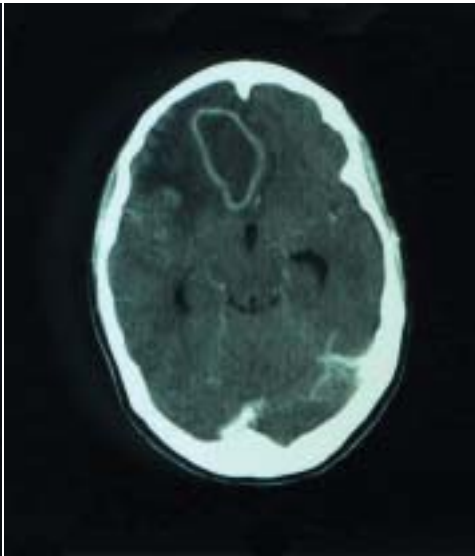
She represented 5 weeks later with similar symptoms. Her CRP and white cell count were normal. This contrast enhanced CT scan shows the characteristic appearances of an intracerebral abscess with a thin walled cavity surrounded by cerebral oedema. She underwent an emergency craniotomy to marsupialise the abscess. She also underwent bilateral sphenoidectomies and a partial ethmoidectomy to treat the infective source.
